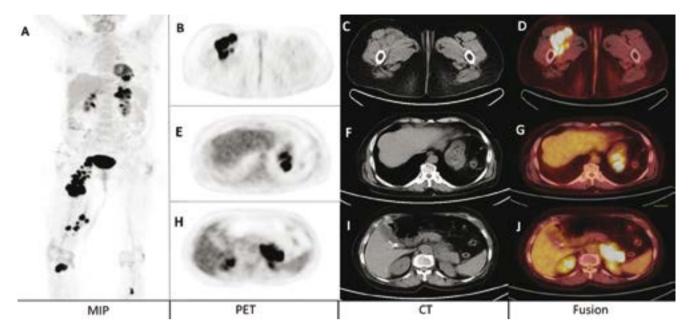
The Whole body MIP image showed multiple foci of increased FDG uptake in the right thigh, stomach, pancreas, pelvic lymph nodes and both tibiae (A); The axial images demonstrated increased FDG uptake throughout the right thigh muscles (B–D); stomach wall (E–G) and pancreatic body and tail (H–J)
